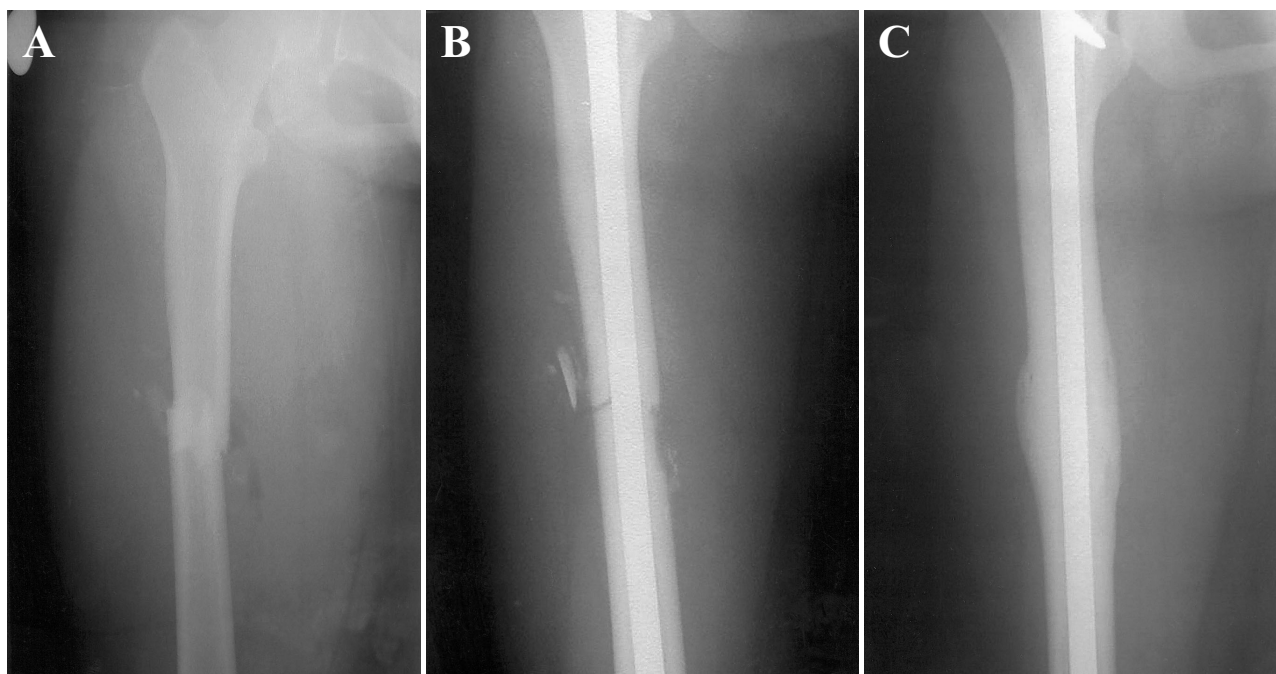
(A) A 22-year-old female, initial X-ray with fractured femur. (B) The same patient, immediately post-op showing intramedullary nail and fracture reduction. (C) The same patient, 6 months later showing callus formation and complete healing.
